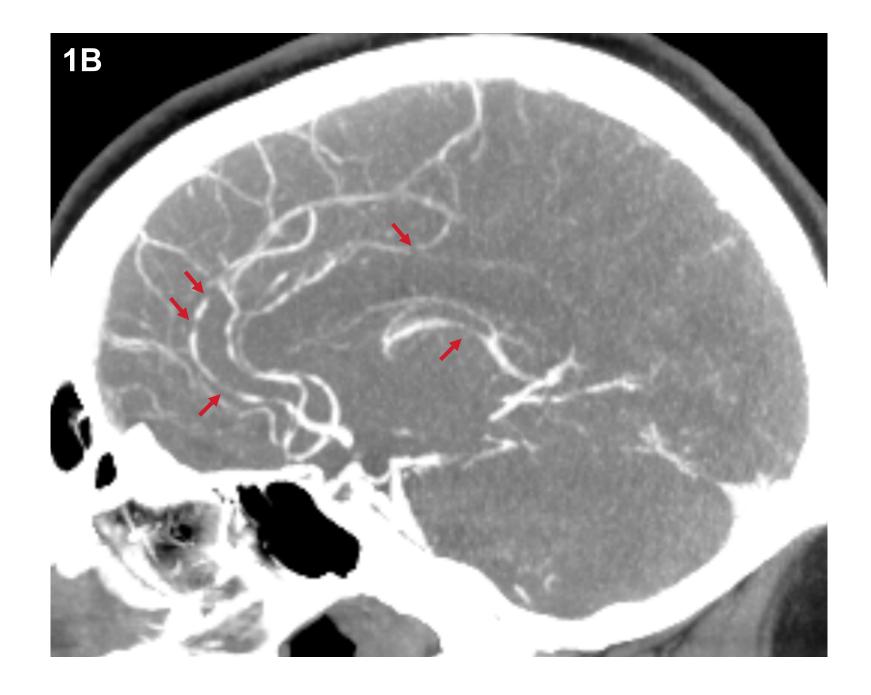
CT Angiography of the Head
